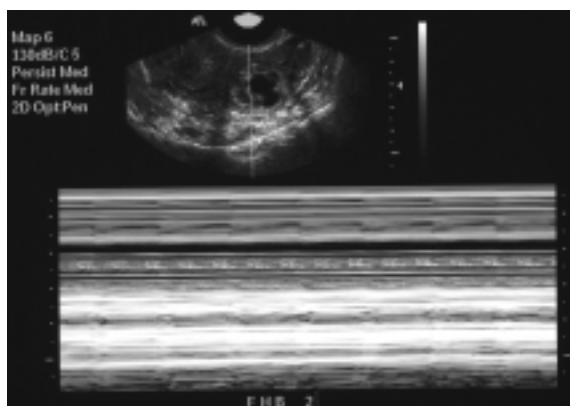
M-mode Doppler US trace of the echogenic component in the left adnexal mass.
